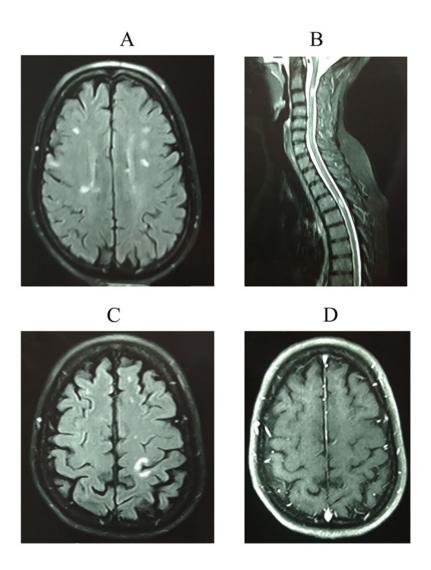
Brain and cervical MRI
